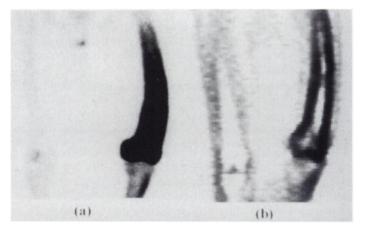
(A) Technetium-99m-MDP bone scan of the same patient as in Figure 2. (B) Coronal [¹⁸F]FDG PET of femora showing the cortical distribution of tracer
